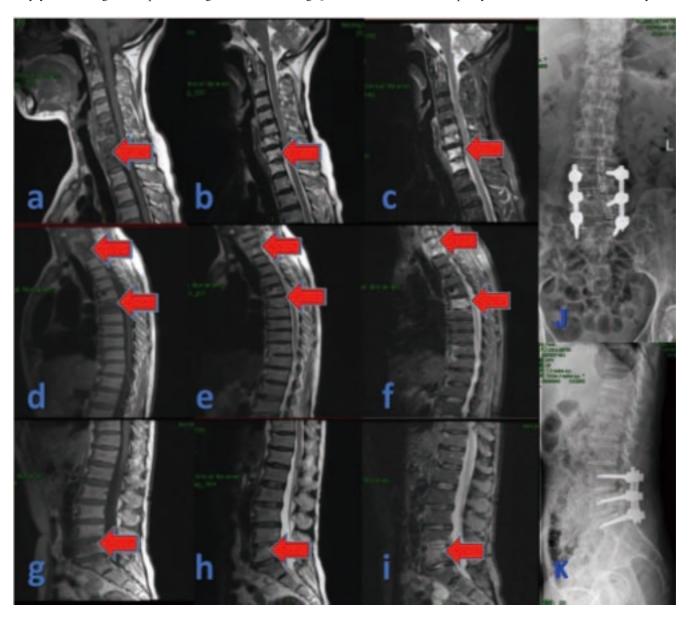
Magnetic resonance imaging (MRI) of a 62-year-old woman with brucellar spondylitis showed that the C5-T1 (a, b, c), T5-T6 (d, e, f), and L4-L5 (g, h, i) intervertebral discs and vertebral bodies were hypointense on T1-weighted images (T1WI) and heterogeneous on T2-weighted images (T2WI) and short-T1 inversion recovery (STIR). Follow up images show that the L4-S1vertebral body is fixed by the nail rod, and the position is stable without looseness 6 months after discharge (J, K).
